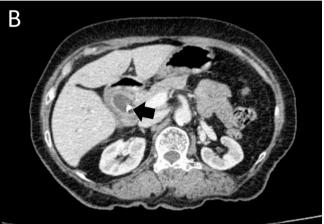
Pre-operative CT scan: (A) a dilated common bile duct (*) with an ampullary lesion; (B) a plastic stent (black arrow) in place.
